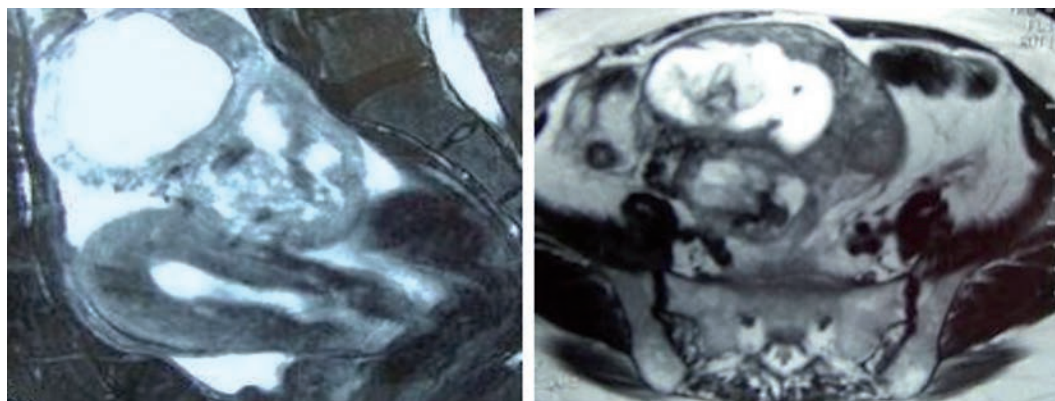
Magnetic resonance imaging showing a solid component with a relatively high intensity, whereas the cystic part shows a mixture of low- and high-intensity features on a T2W1 image
